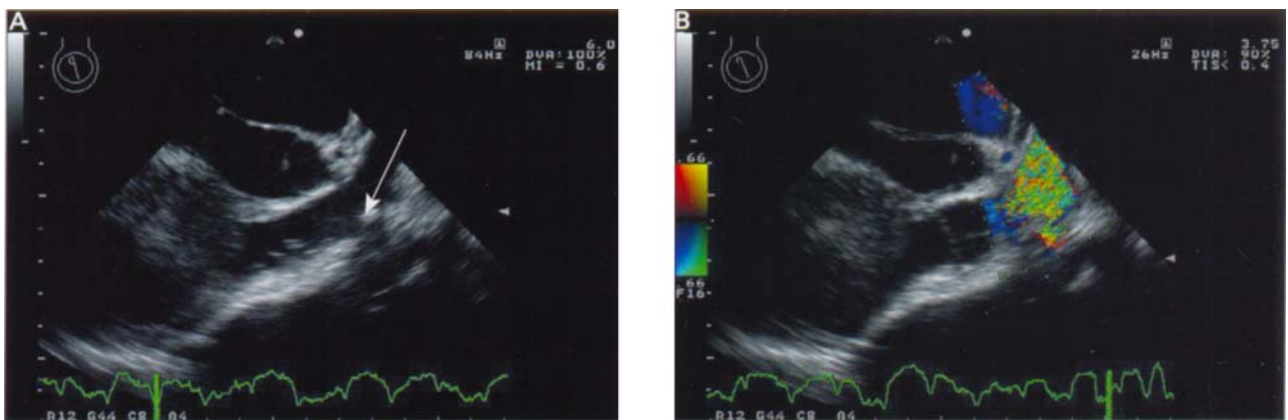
Pulmonary artery anastomosis to the outflow cannula of a pulsatile right ventricular assist device (RVAD; arrow), imaged in (A) a longitudinal view of the pulmonary artery. (B) Colour flow Doppler shows pulsatile flow as a colour mosaic.
